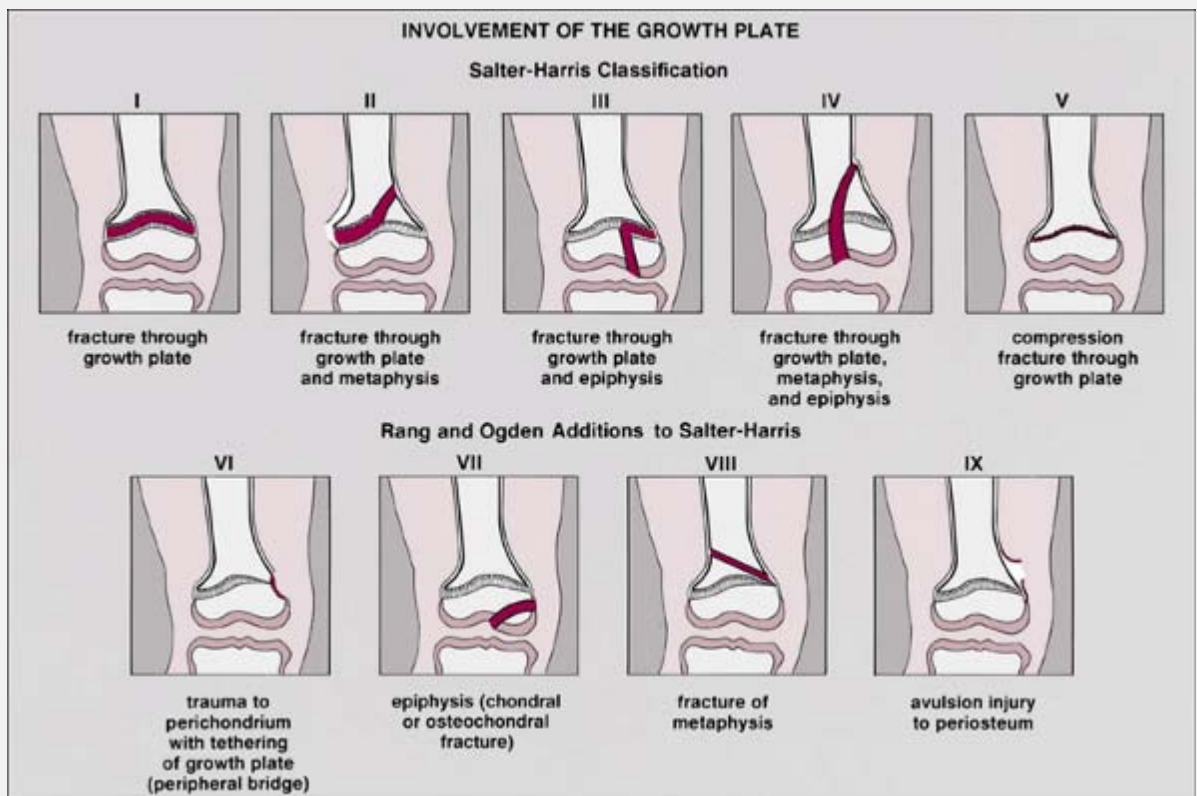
Special features. Factors in the radiographic evaluation of a fracture: special features.
